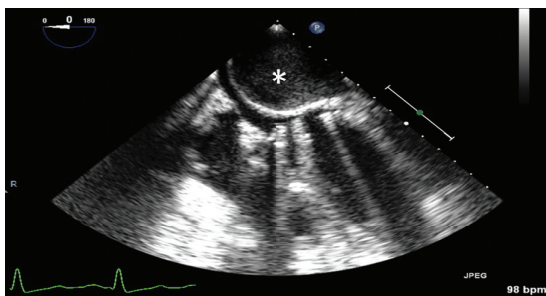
Transesophageal echocardiography, mid-esophageal 4-chamber view, demonstrating a mass (asterisk) that nearly obliterates the left atrium.
